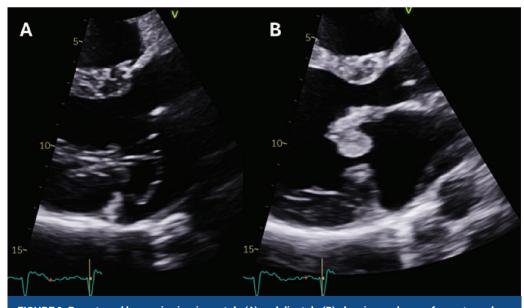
Parasternal long axis view in systole (A) and diastole (B) showing prolapse of an extremely myxomatous and thickened anterior mitral leaflet.
